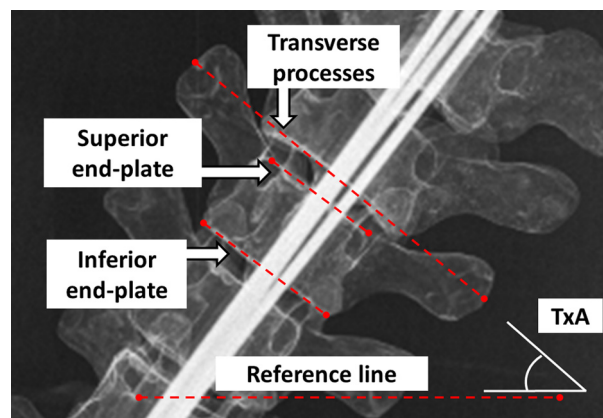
Radiographic lines used for curvature measurement for a single thoracic vertebra in postero-anterior radiographic projection. TxA = transverse process angle.
